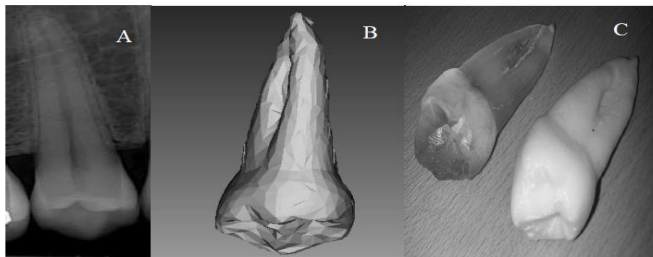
Showing A) an example of a micro CT (computer tomography) image of human tooth with B) a digitized model and C) 3D printing models using SLA by Formlabs printer (transparent) and FDS by Maker Boot (white). The length of the tooth is about 20mm
